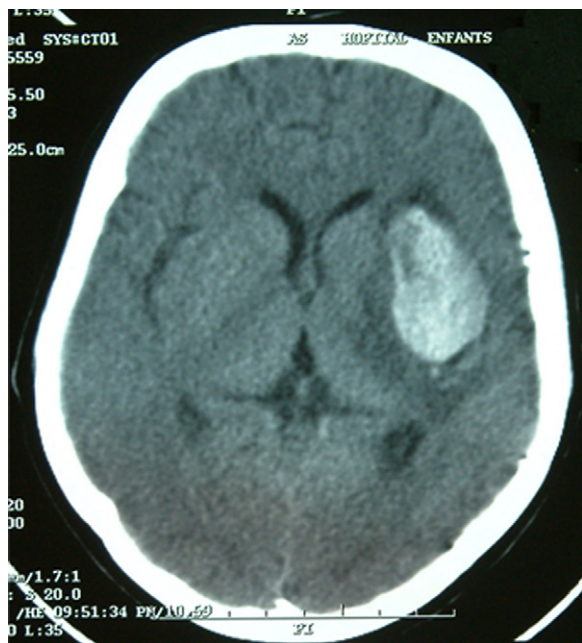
Axial, nonenhanced CT scan shows hemorrhagic infarction of paraventricular infarct with edema.
